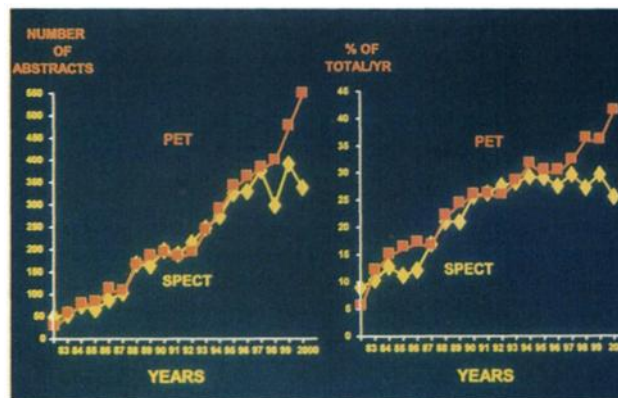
Continuing growth of PET and SPECT in presentations at the annual SNM meeting over the past 2 decades.
